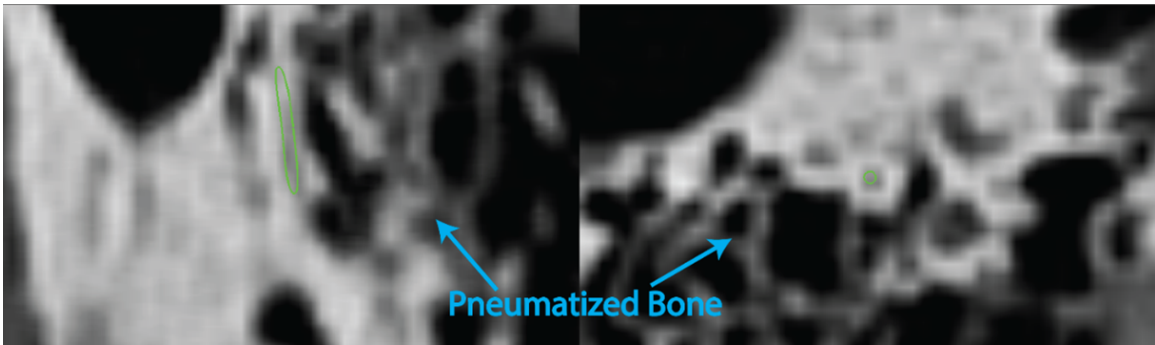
Example image of a chorda in CT images (outlined in green). Note the faint appearance of the structure along with similar image features occurring from pneumatized bone
